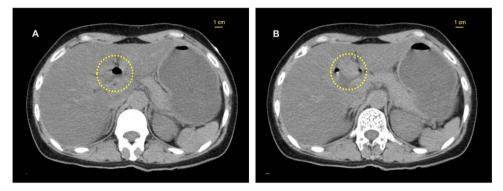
Plain CT of the trunk showing free gas surrounding the porta hepatis (A) and the pyloric side of the stomach (B). The dotted circles indicate the free gas. CT, computed tomography.
